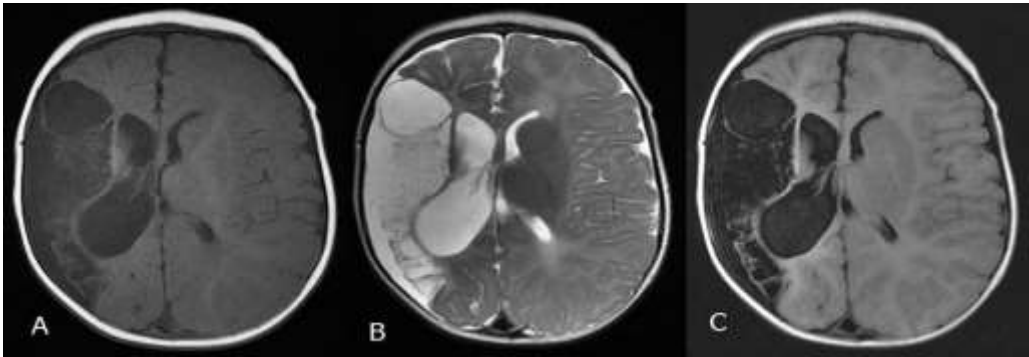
A 6 months old infant with presumed ischemic perinatal stroke who presented at the age of 6 months with infantile spasms and evidence of right sided pathologic handedness and left moderate hemiparesis. A, B and C) MRI brain on axial T1, T2 and FLAIR sequences demonstrating cystic gliosis and ex-vacuo dilatation of the right lateral ventricle in the territory supplied by the right middle cerebral artery.
